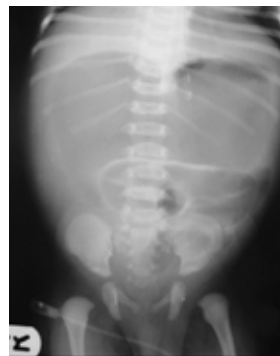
Anteroposterior abdominal radiograph showing disproportionately large loops of bowel.
